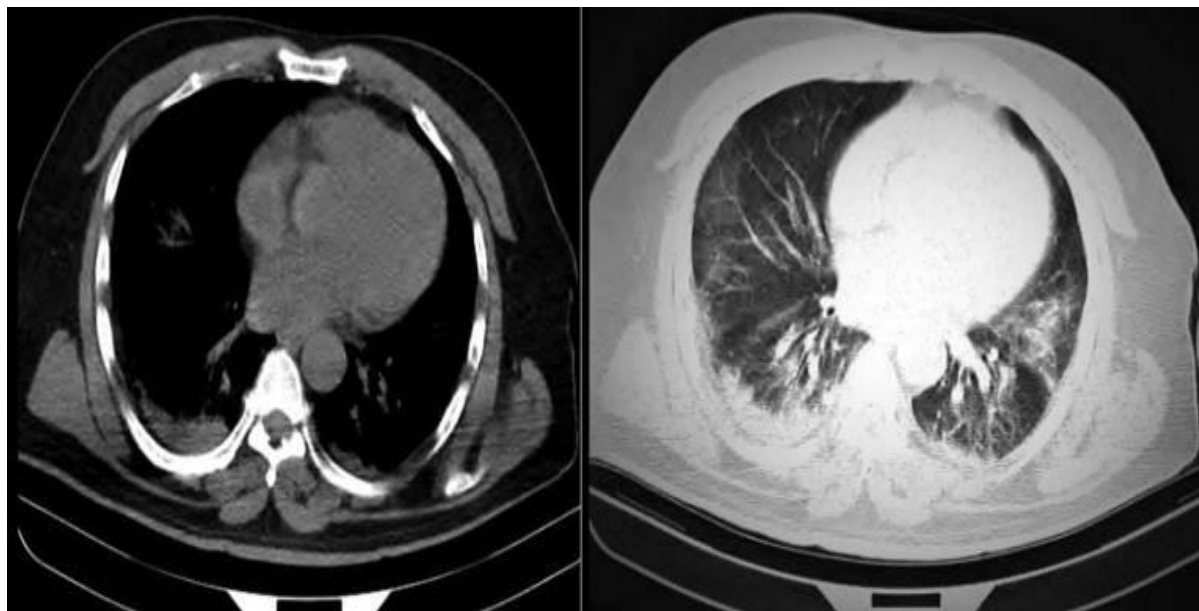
Lung CT showed diffused consolidations and ground-glass opacities in both lungs, and bilateral pleural effusion.
